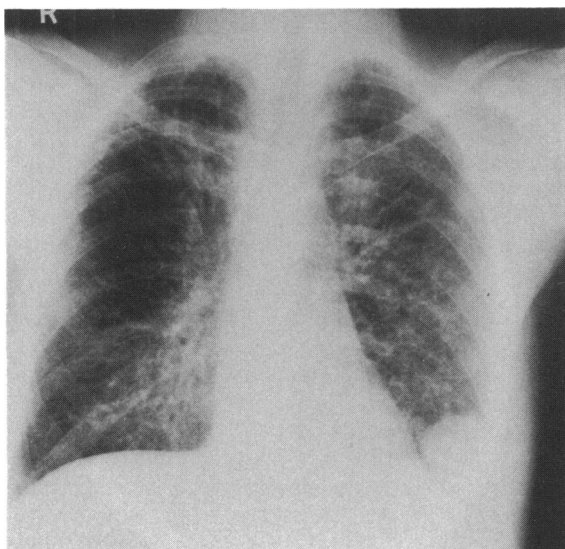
Chest radiograph showing a further increase in interstitial shadowing.
